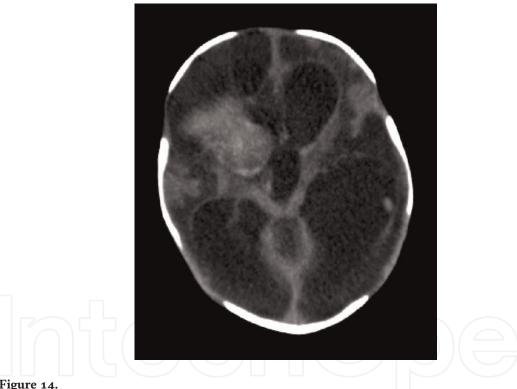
The CT scan of the brain of the preterm neonate with posthemorrhagic hydrocephalus with diffuse hypoxic-ischemic brain injury.
